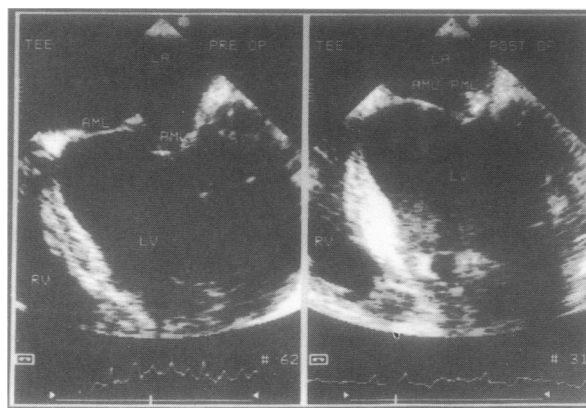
Preoperative (left panel) and postoperative (right panel) echocardiograms (transesophageal 4-chamber views) showing anatomic correction. In the postoperative panel, the dense echoes behind the posterior mitral leaflet are from the Teflon felt.
